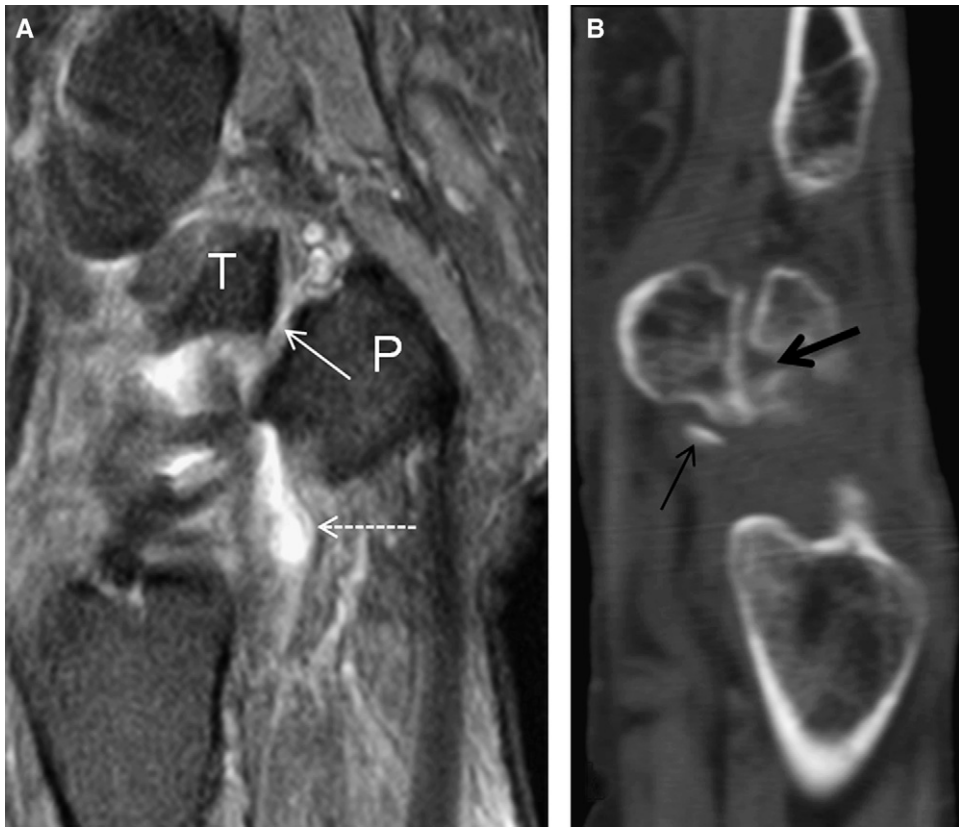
Pisotriquetral joint degenerative change and injury. Sagittal proton density weighted fat-saturated magnetic resonance image (A), demonstrating pisotriquetral joint (PTJ) osteoarthritis. Notice the chondromalacia (white arrow), small joint effusion in the proximal PTJ recess (dotted white arrow). P = pisiform; T = triquetrum. Sagittal reformat CT image (B) in a different patient demonstrating an intra-articular triquetral injury (thick black arrow) with a small bone fragment in the proximal PTJ recess (thin black arrow).
